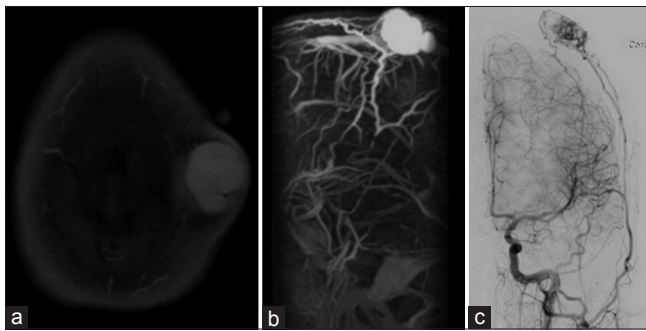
(a) Magnetic resonance image of the lesion. (b) Magnetic resonance angiography of the lesion revealing a vascular mass lesion. (c) Cerebral angiographic imaging of an arteriovenous malformation in the left parietal region
